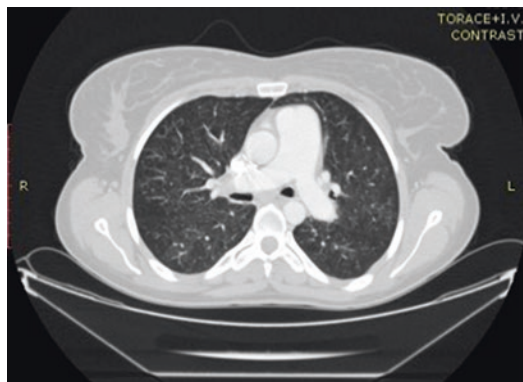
High-resolution computed tomography in a patient with PVOD: centrilobular ground-glass opacities are observed
